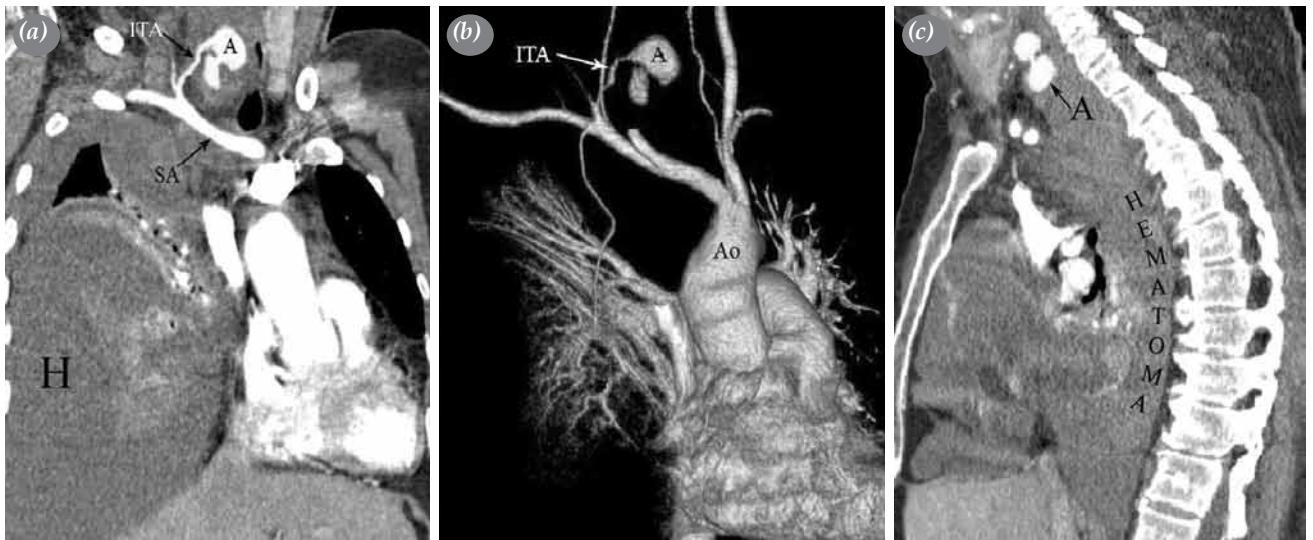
(a) Preoperative computed tomography angiography demonstrating the ruptured aneurysm of the right inferior thyroid artery and extravasation of contrast media. The right hemithorax was filled with hematoma. (b) The right pulmonary arteries and bronchus extending upward due to hematoma. (c) Sagittal view of the right hemithorax showing a large hematoma. ITA: Inferior thyroid artery; A: Aneurysm; SA: Subclavian artery; H: Hematoma.
